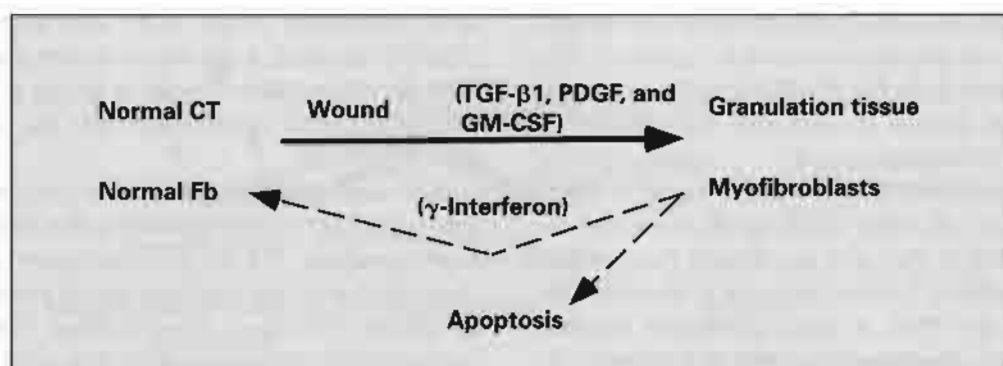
Role of growth factors and cytokines in regulating myofibroblast development and regression. (CT) Connective tissue; (Fb) fibroblast; (GM-CSF) granulocyte-macrophage colony-stimulating factor; (PDGF) platelet-derived growth factor; (TGF- β 1) transforming growth factor β 1.
